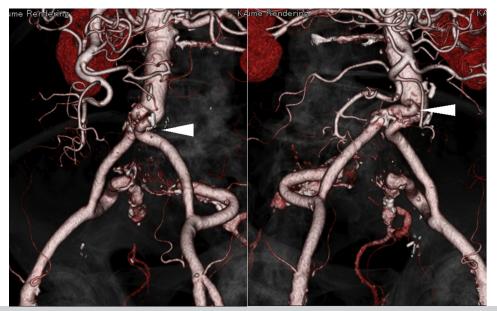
Three-dimensional computed tomography revealed that the bilateral iliac leg of 8 mm of the Y-graft was extremely kinked (*arrowheads*).
